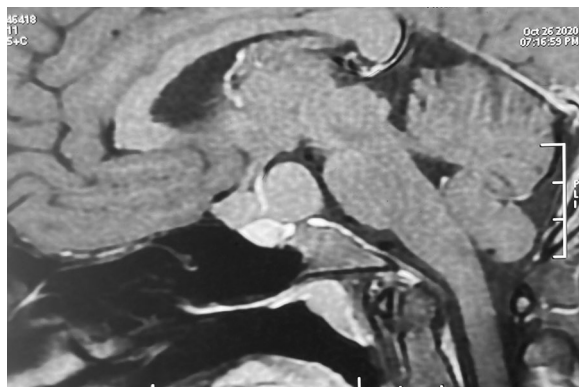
MRI brain T1 contrast image showing mild peripheral enhancement of the lesion
